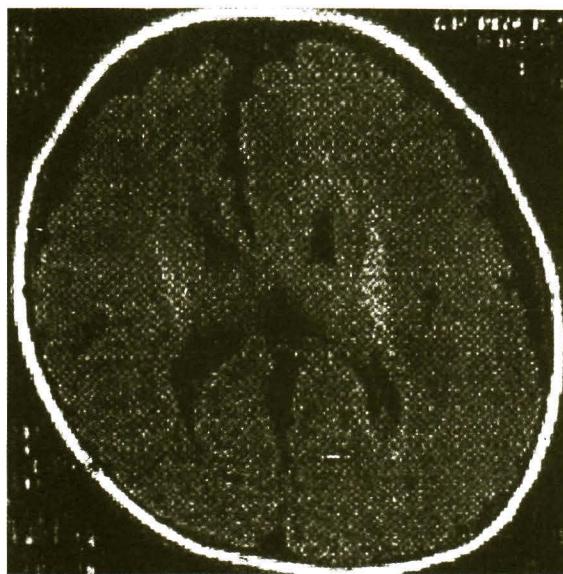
MRI of the brain demonstrates hemimegalencephaly of the left cerebral hemisphere.
